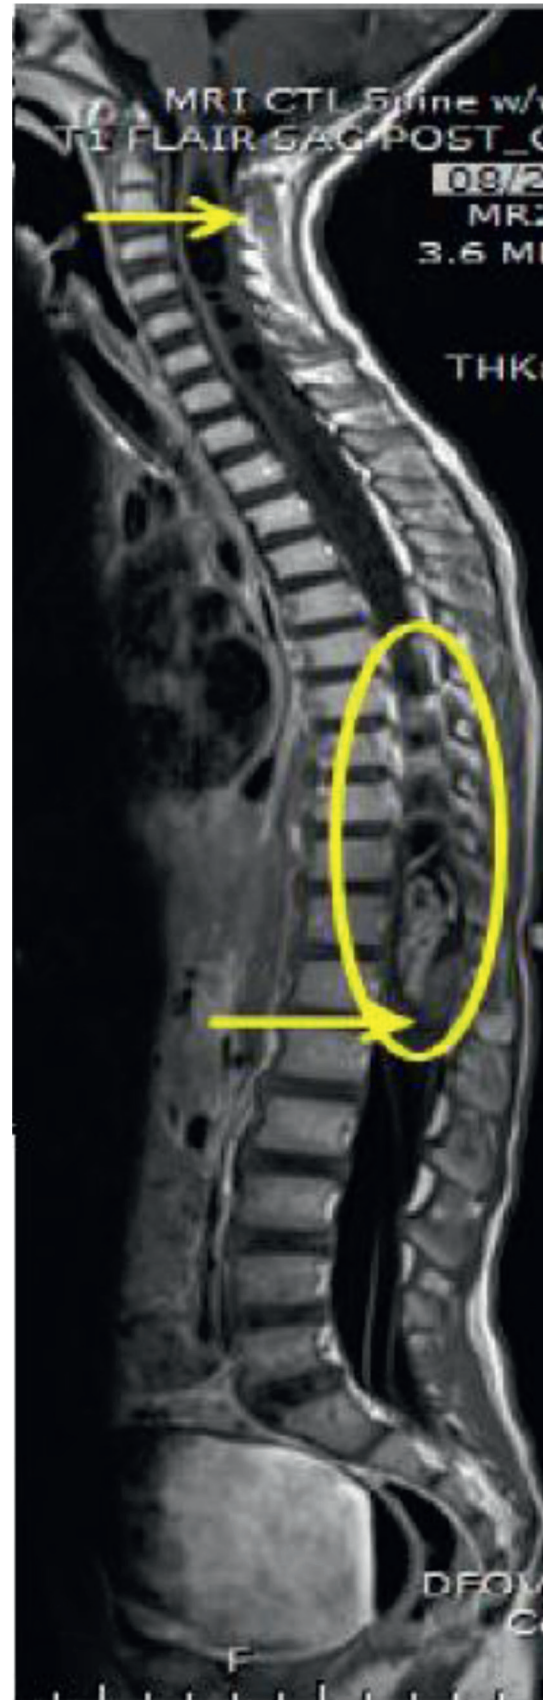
T1 sagittal MRI at presentation of neurologic symptoms. Tumor is within yellow circle. Syrinx is in between yellow arrows.
